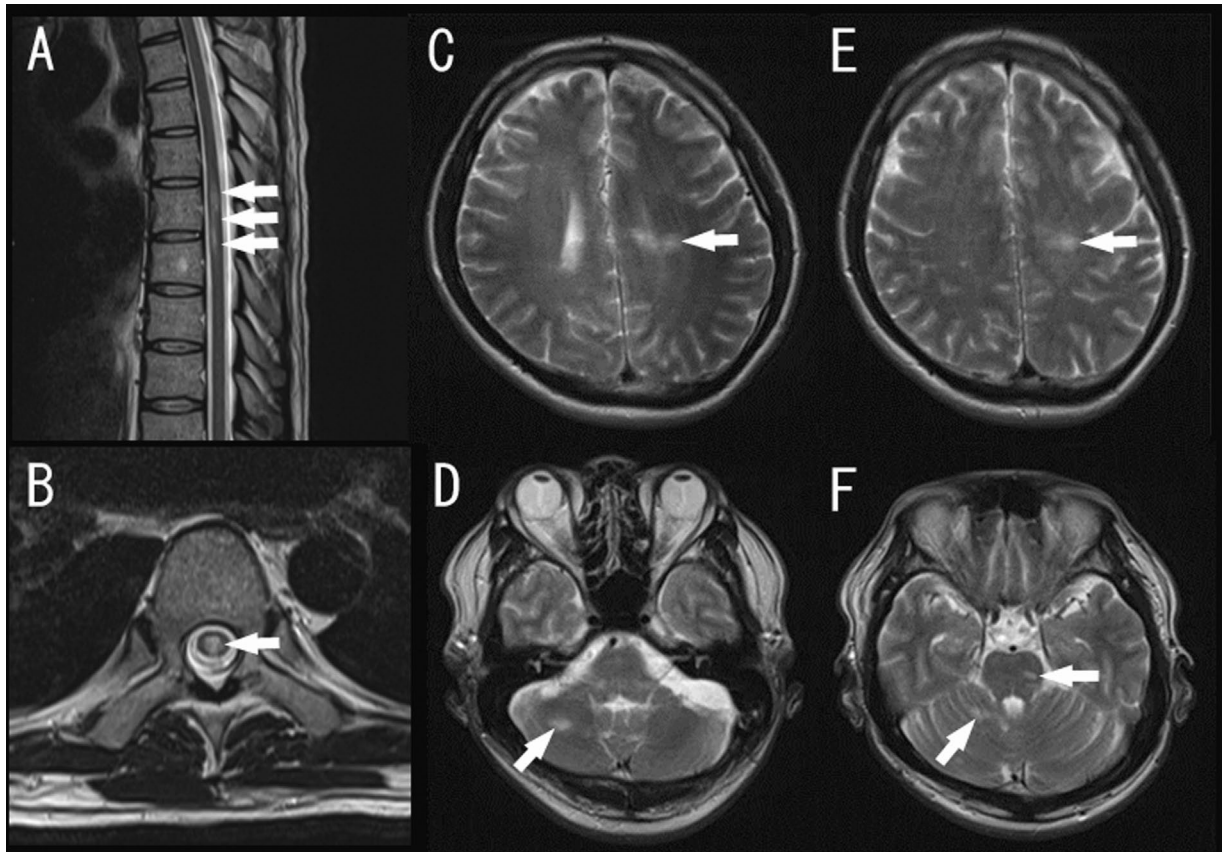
MRI during the third hospitalization period. (A) Spinal MR T2WI (TR/TE=4200/89) showed a T2 high-signal lesion around the level of Th6-7 (arrow). (B) This lesion was located in the center of the spinal cord (arrow). (C and E) A T2-high signal lesion was present around the lateral ventricles (arrow). (D and F) Lesions in the right cerebellar hemisphere and the left side of the pons (arrow).
